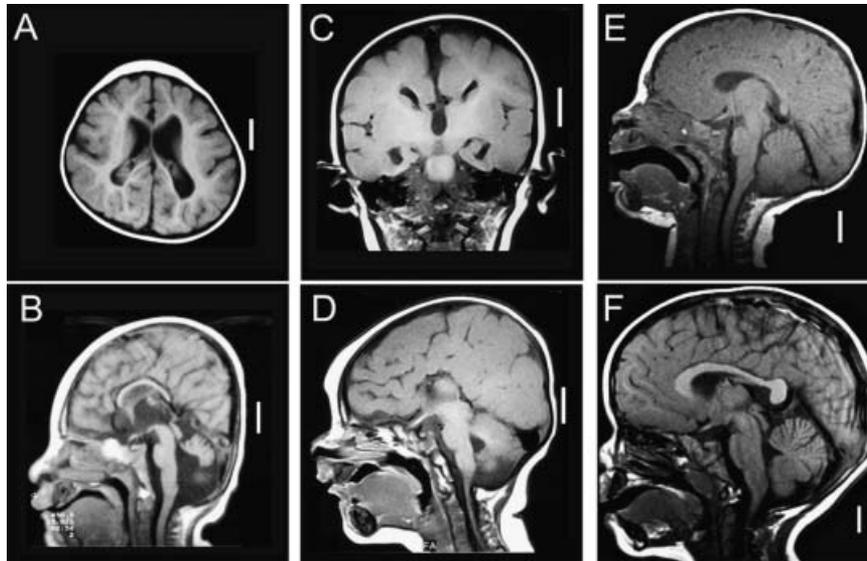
T1-weighted brain MRI of Patient 2 at 6 months (A,B) and Patient 4 at 18 months (C,D) obtained in the axial (A), coronal (C) and sagittal (B,D) planes. MR images of Patient 2 (A,B) show reduced brain size, enlarged ventricles and a thin corpus callosum when compared to an age and gender matched control (E). The dramatic hypoplasia of the cerebellum and the thin corpus callosum are evident in (B). The striking absence of the corpus callosum in Patient 4 is evident in (C,D). Panels E,F show sagittal images of an unaffected 6-month-old boy (E) and an unaffected 18-month-old girl (F) for comparison. Scale bars = 2 cm.
